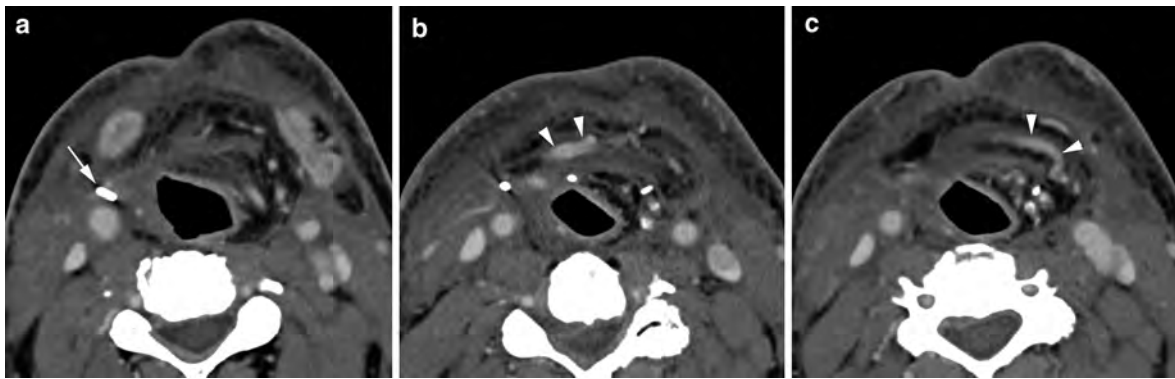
Sequential axial contrast-enhanced CT images through the mid-neck in a patient after total laryngectomy and total pharyngectomy, demonstrates a radial forearm flap forming a neopharynx. The surgical clip at the external carotid
